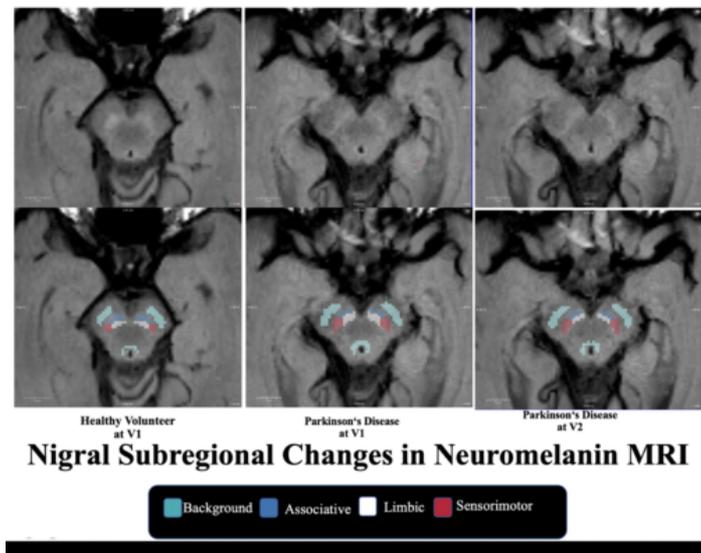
(a): Nigral subregional changes in Neuromelanin MRI
